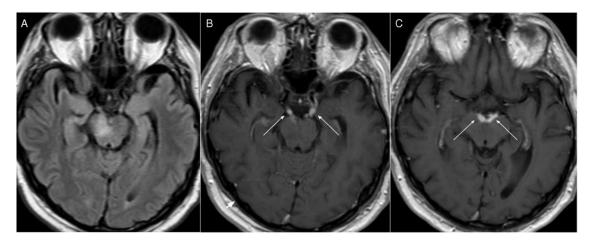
MRI findings in Bickerstaff brainstem encephalitis. (A) Axial T2-weighted FLAIR image showing hyperintensity within the right aspect of the midbrain. (B, C) T1-weighted, contrast-enhanced axial images shows intense enhancement of the cisternal segments of the third nerves bilaterally (white arrows).
